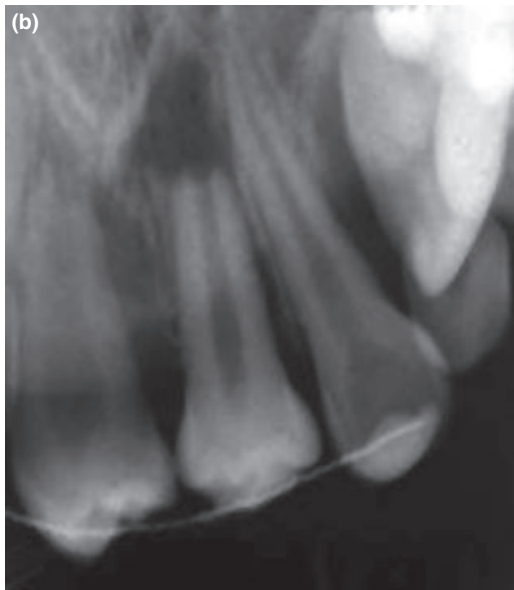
Patient 3: a) Intra-oral photograph of a 11-year-old boy with two lower premolars transplanted to anterior maxilla. b) Immediate radiographic control. c) Radiography after 5 months; it shows two transplanted premolars with entire root periphery surrounded by normal size, newly formed periodontal space with an intact *lamina dura* and bone formation.
